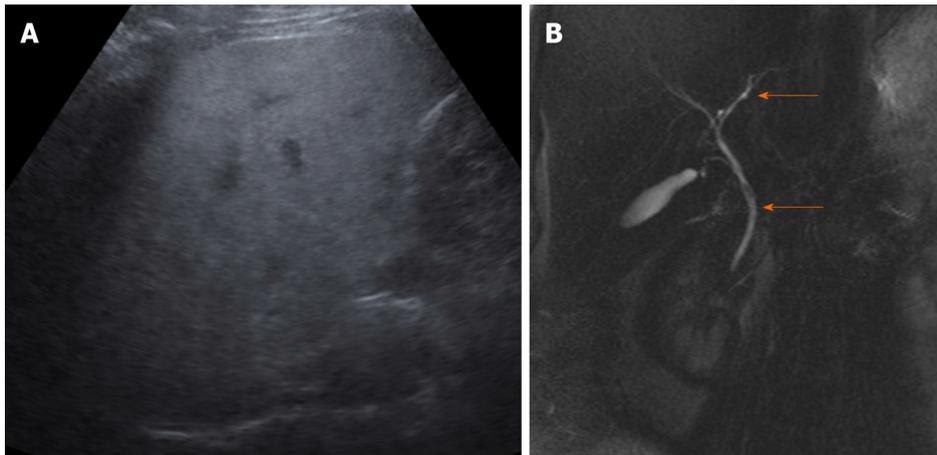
The abdominal ultrasound. A: Diffuse fatty infiltration of liver; B: Normal common bile duct and intrahepatic biliary ducts (orange arrows) in magnetic resonance cholangiopancreatography 3D image.
